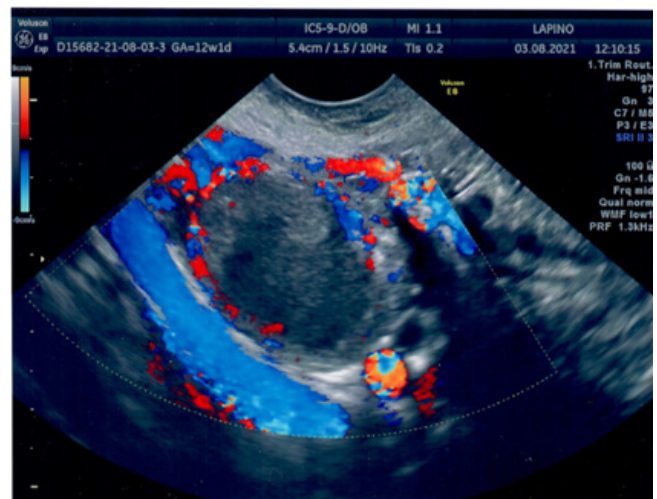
Doppler ultrasonography of the endometrial cyst. Longitudinal transabdominal scan. Multiple coloured loci of blood flow and low resistive index values
